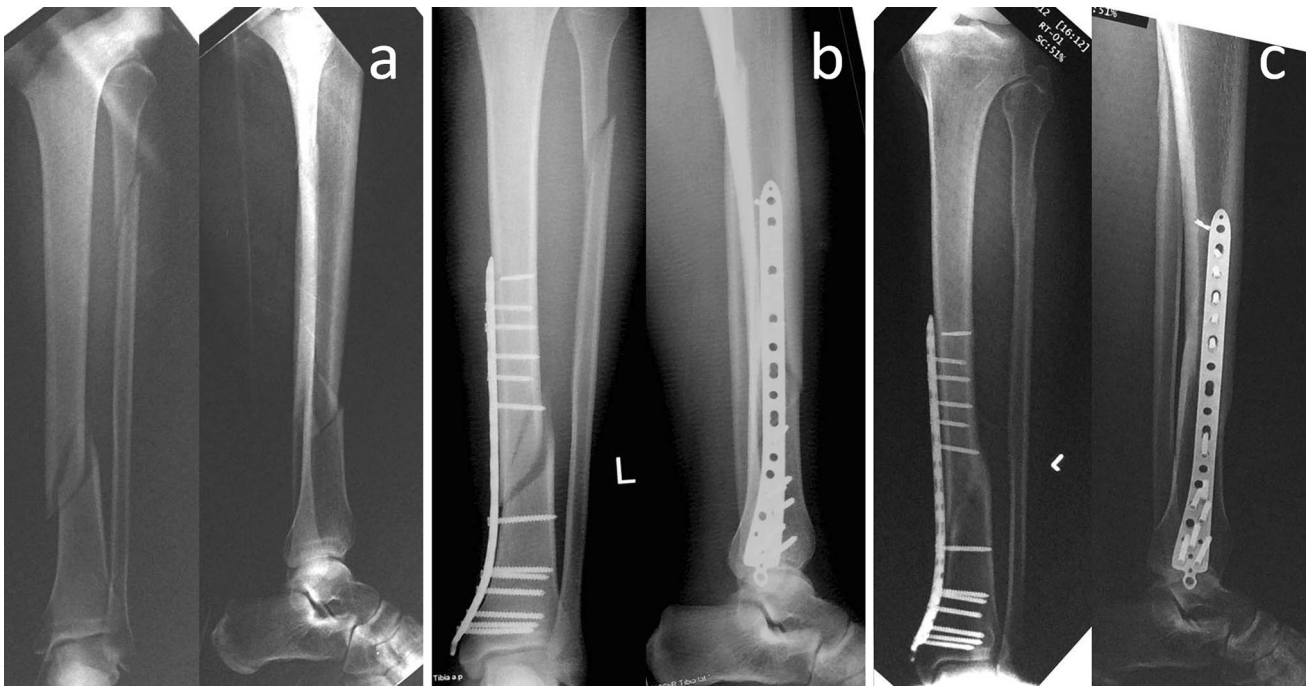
A patient treated with MIPO. a Pre-operative, b early post-operative, and c final radiograph
